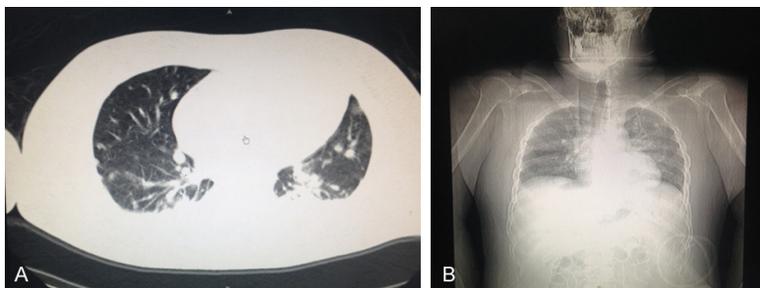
Pulmonary CT scan of the axial (A) and coronal positions (B) showing the clinical metastasis of the fusocellular sarcoma. CT: computed tomography.
